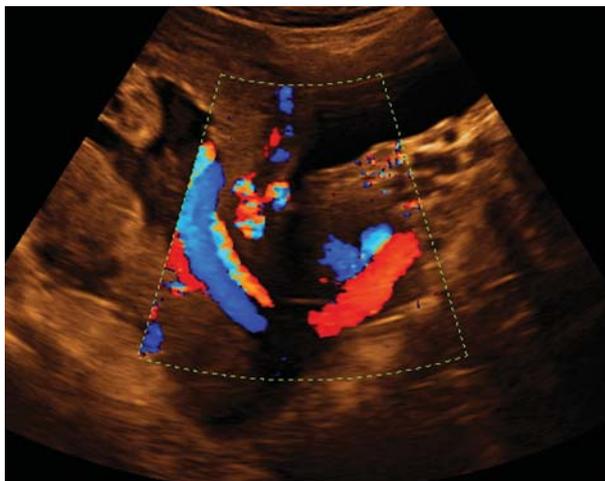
Labour ward ultrasound showing a cord prolapse at 26 weeks gestation.
